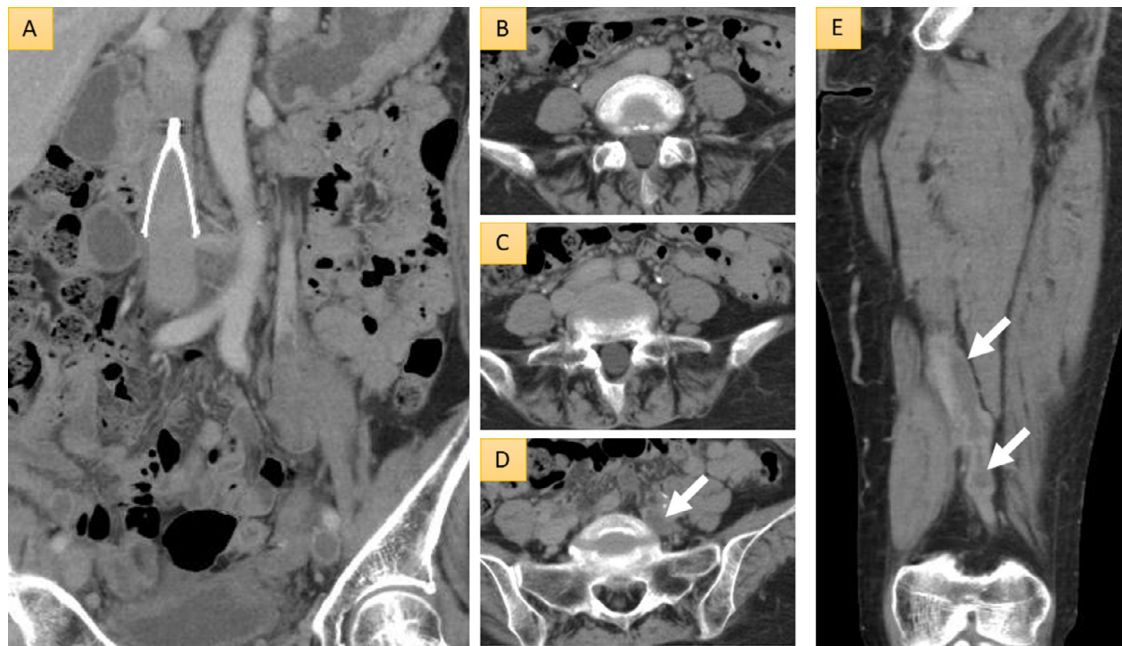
Enhanced computed tomography on postoperative day 11. (A) Coronal view of the abdomen, focusing on the abdominal aorta and inferior vena cava, (B-D) axial views, showing the common iliac vein and artery at the level of the fifth lumbar vertebra along with an occlusive thrombosis of the left common iliac vein (white arrow), and (E) coronal view of the left thigh, indicating an occlusive thrombosis of the left superficial femoral vein (white arrow).
